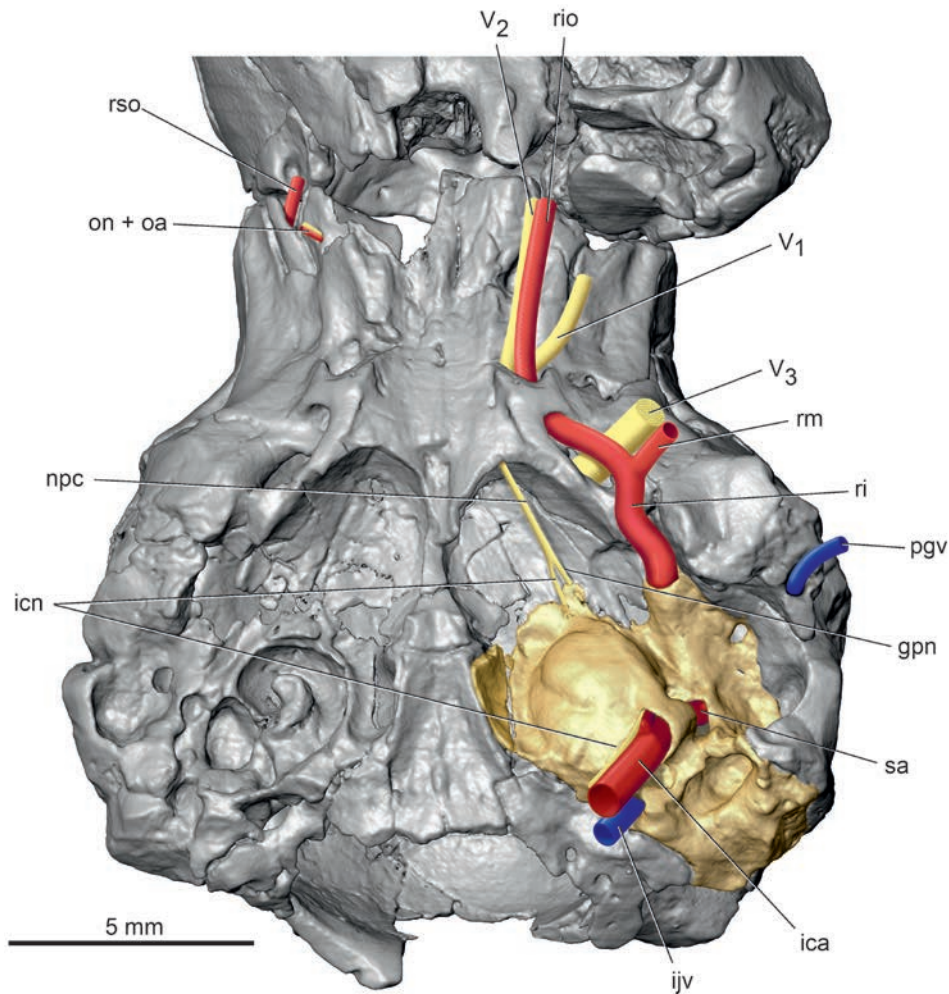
Palaeoryctid mammal *Eoryctes melanus* Thewissen and Gingerich, 1989, UM 68074 (UM locality SC-133, Clarks Fork Basin, Wyoming, USA; early Wasatchian Land-Mammal Age, early Eocene), isosurface of cranium rendered from CT scans in ventral view, with neurovascular structures reconstructed based in part on Avizo segmentation (left petrosal in gold; arteries in red; veins in blue; nerves in yellow). The alisphenoid canal is broken on the left side in UM 68074 (see Fig. 1), but is reconstructed here to show the course of the ramus infraorbitalis. Abbreviations: gpn, greater petrosal nerve; ica, internal carotid artery; icn, internal carotid nerve; ijv, internal jugular vein; npc, nerve of pterygoid canal; on + oa, optic nerve and ophthalmic artery; pgv, postglenoid vein; ri, ramus inferior; rio, ramus infraorbitalis; rm, ramus mandibularis; rso, ramus supraorbitalis; V<sub>1</sub>, ophthalmic nerve, first division of trigeminal nerve; V<sub>2</sub>, maxillary nerve, second division of trigeminal nerve; V<sub>3</sub>, mandibular nerve, third division of trigeminal nerve.
